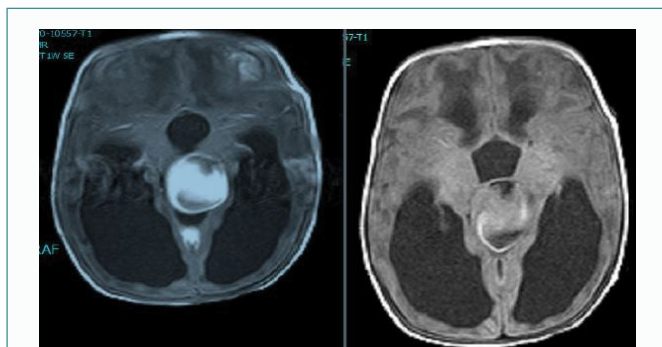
Pre-operative MRI Brain T1 with and without contrast axial view show intra pontomesencephalic colloid cyst with marked hydrocephalus.
